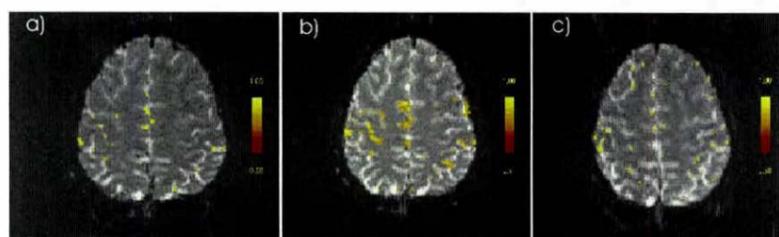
Cortical activation within the anterior and posterior SMA a) prior to DWI, b) immediately after DWI and c) one week after DWI. There is an increase of cortical activation of more than 100% in anterior as well as posterior SMA. The third examination one week after DWI shows reduction of activation to approximately baseline values.
